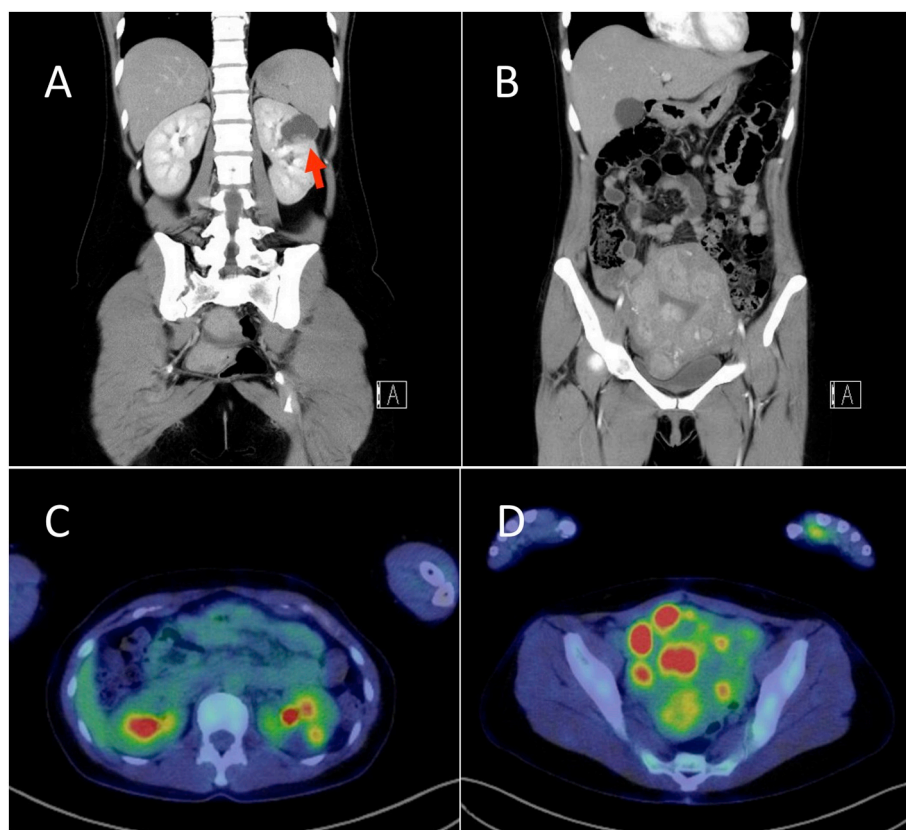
Contrast enhanced computed tomography (CECT) revealed a left cystic renal cell tumor 4 cm in diameter containing a solid component (A) and a large multiple uterine myoma (B). 18F-Fluorodeoxyglucose positron emission tomography (FDG-PET) revealed FDG uptake in a left cystic renal tumor (maximum standardized uptake value [SUVmax] = 4.58) (C) and uterine myoma (SUVmax = 17.13) (D). There was no evidence of metastasis.
